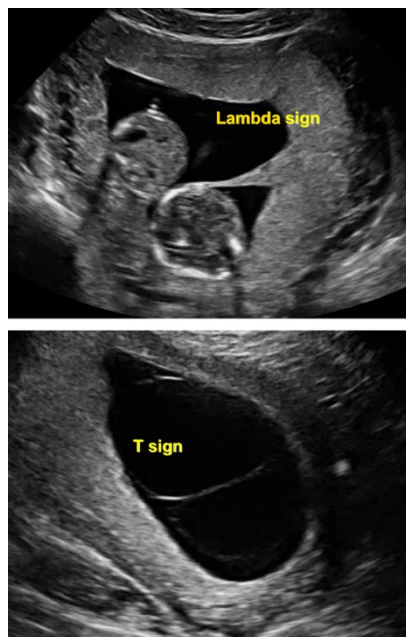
Ultrasound differentiations of Chorionicity in Twin Pregnancies: Lambda vs T sign (62)
